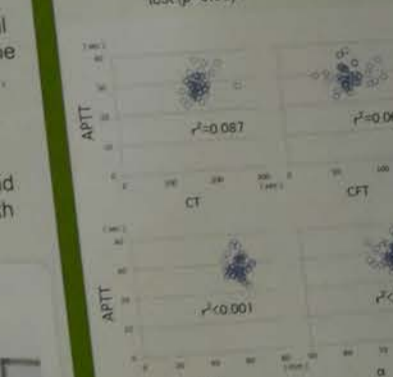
Relation between INTEM parameters and APTT. Coefficient of determination, R-Square, between CT and APTT.
